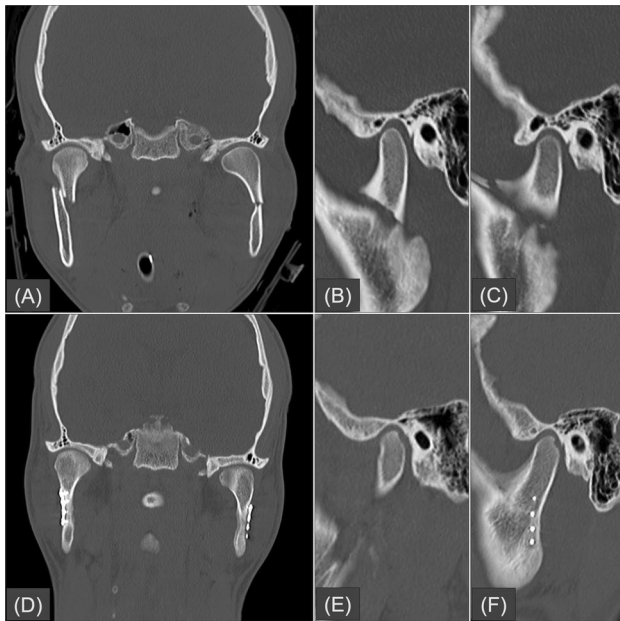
A 21-year-old man had mandibular symphysis (not shown), right condylar base (B), and left (C) condylar base fractures. The coronal reformatted image of the initial CT showed displacement at the right condylar fracture site and angulation at the left condylar fracture site (A). However, no condylar head fracture or pre-existing condylar degeneration was detected on the initial CT scan. The patient underwent surgical treatment for his bilateral mandibular fractures (D). A follow-up CT scan 4 months later revealed newly developed postfracture condylar degeneration with bony cortex erosion on the sagittal planes of the right (E) and left (F) temporomandibular joints
